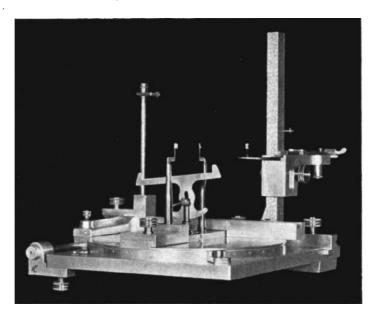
Special Reserve Craniostat built for roentgenographic studies of skulls.
